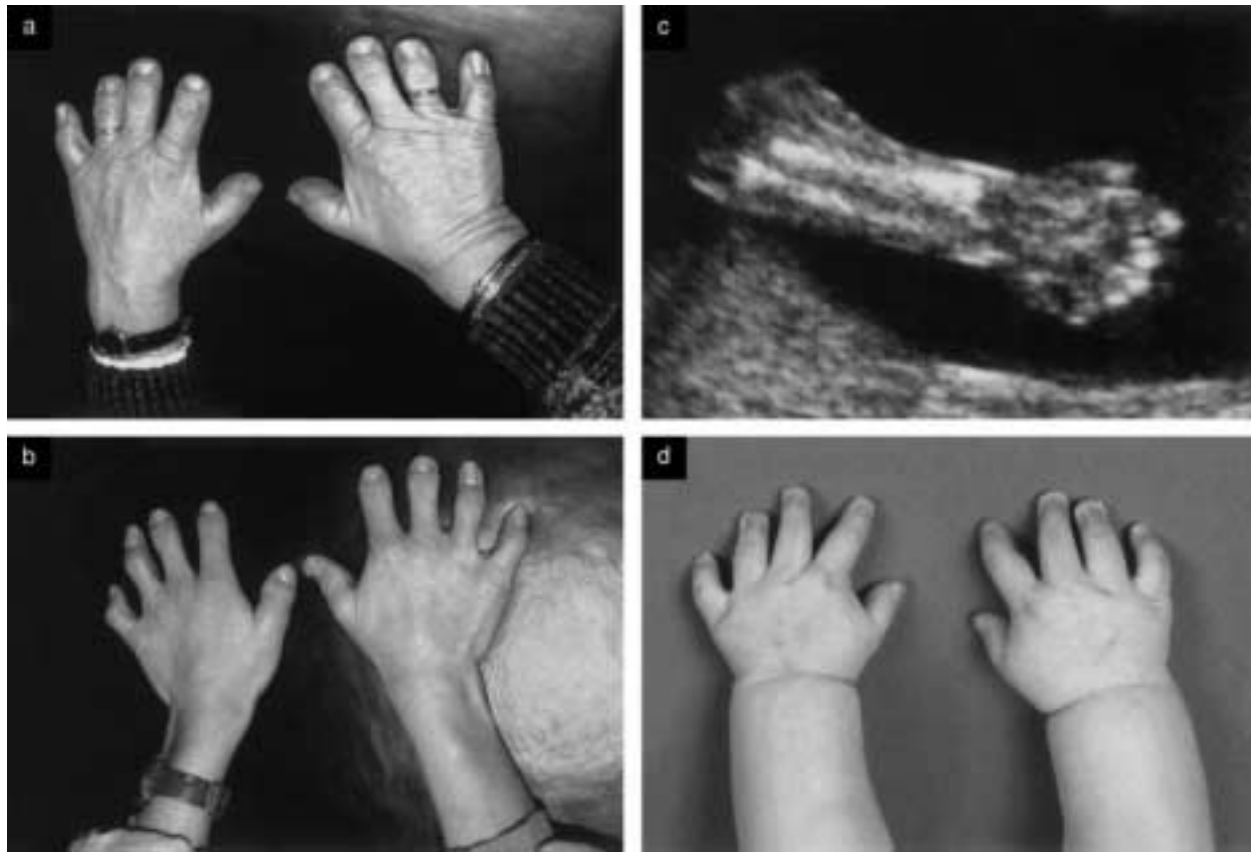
Photographs of the hands of the infant at 6 months (d), the grandmother (a) and the mother (b), showing type A1 brachydactyly. In the ultrasound picture of the fetal hand at 19 weeks (c) the thumb and index finger are extended and the other fingers are slightly bent.
